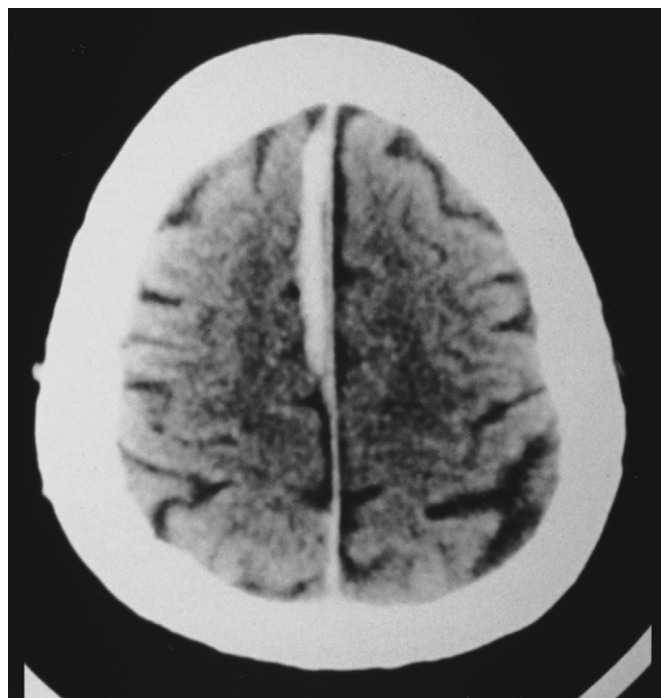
Non-contrast-enhanced computed tomography scan of intrahemispheric acute subdural hematoma.
